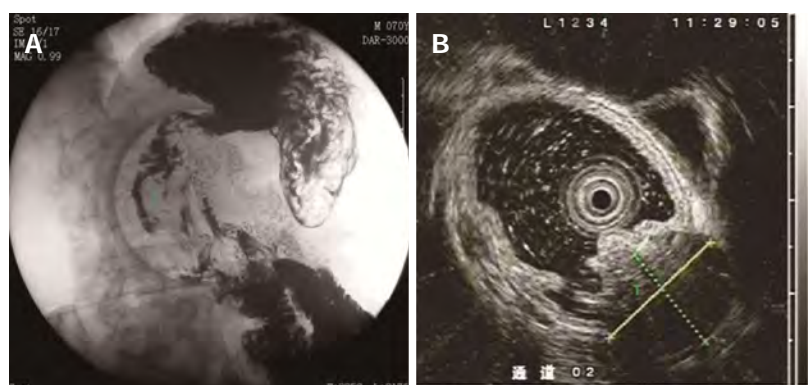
Respective gastrointestinal and endoscopic ultrasonography images. A: Gastrointestinal for case 4; B: Endoscopic ultrasonography for case 23. T: Tumor.
